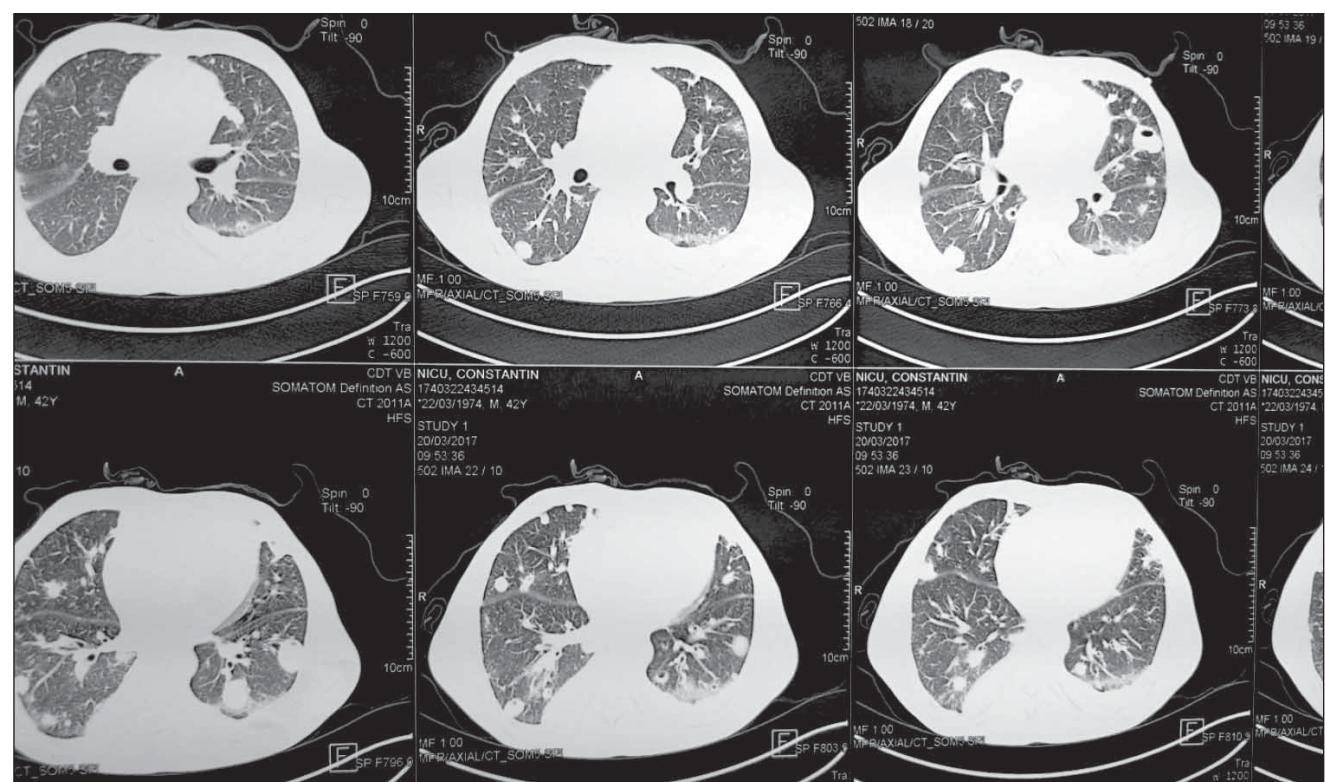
Thoracic CT scan, patient 1 – Pneumatocele. Bilateral pleural effusion.
